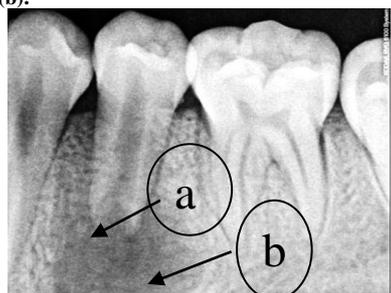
45 presented with incomplete root formation and wide open apex (a). Large periapical lesion in relation to 45 is also evident (b).
